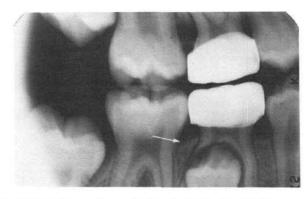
Bite-wing radiograph showing lack of cortical bone and abnormal alveolar bone resorption adjacent to the SSC on the second maxillary primary molar. Note the normal slope of the alveolar bone related to the eruption of the mandibular first permanent molar (arrow).
